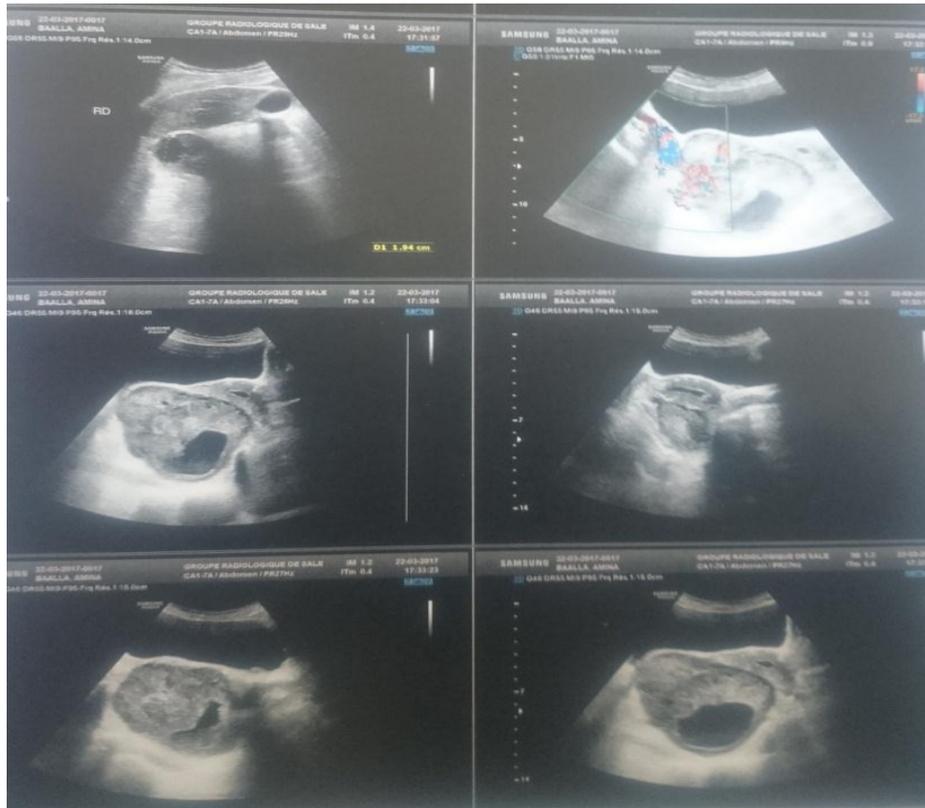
A pelvic ultrasound shows a right lateral pelvic mass with double cystic and tissue component, this lesion is polylobed measuring 11.5 cm for major axis.
